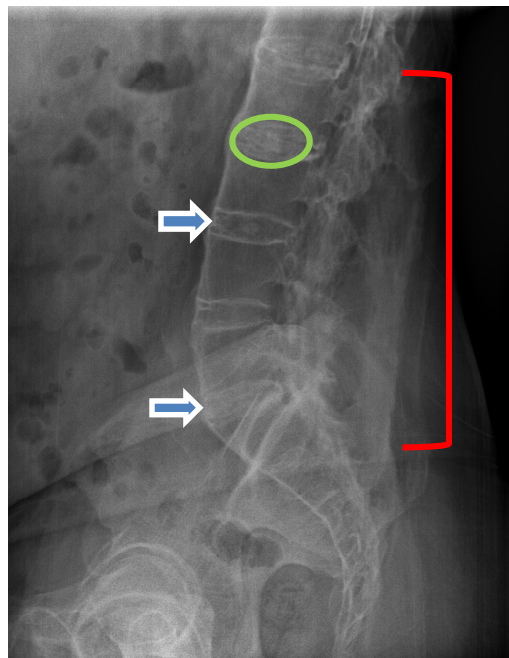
Lateral lumbosacral radiograph demonstrating multiple levels of thin bridging syndesmophytes at anterior disc margins (arrows), loss of the anterior concavity of the vertebral bodies (squared vertebrae), preserved disc spaces, disc (nucleus pulposus) calcifications (L1-L5, green oval), and supraspinous and interspinous ligament ossification (dagger sign on the AP view, red bracket).
